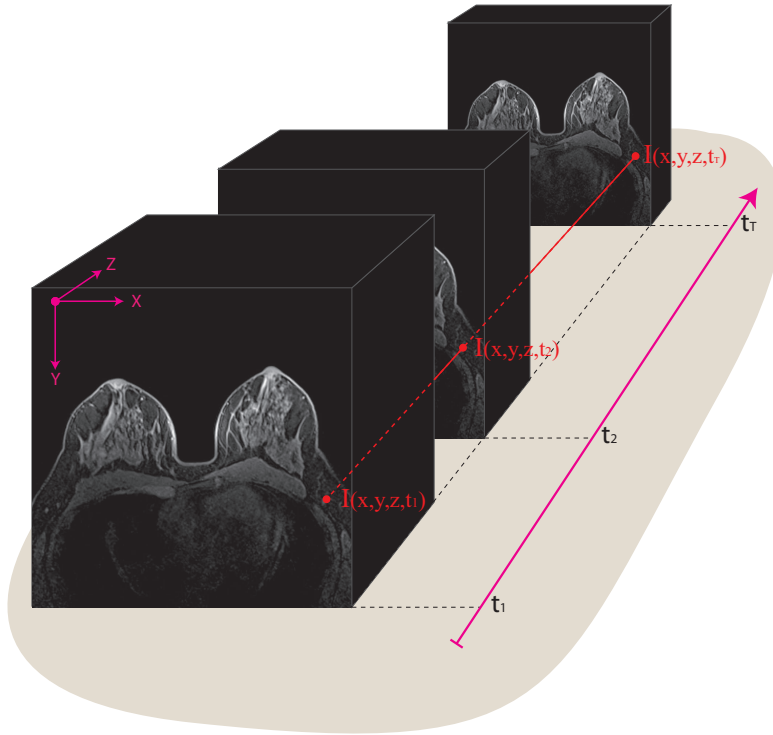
Structure of a DCE-MRI. The four dimensions (3 spatial + 1 temporal) of a complete dynamic study.
